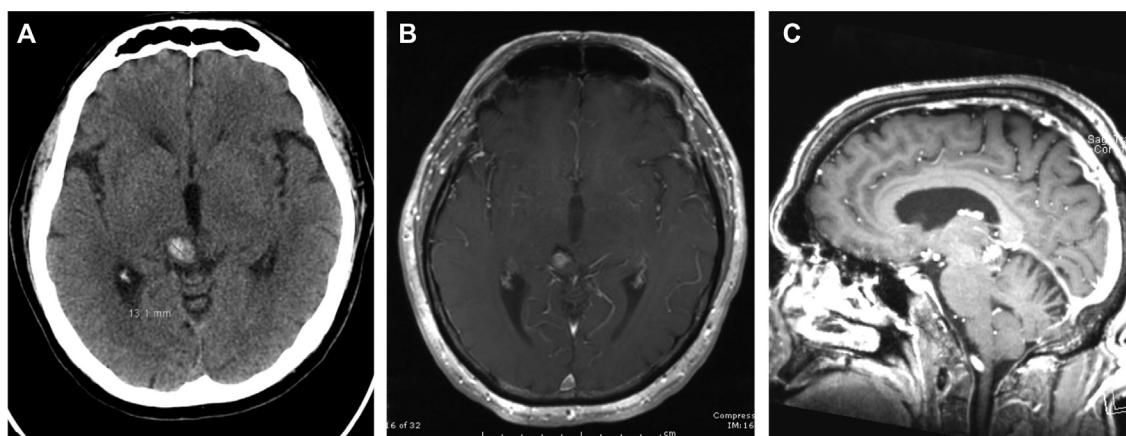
A. Axial non-contrast CT image showing a 1.3 cm brainstem hemorrhage. B. Axial gadolinium-enhanced T1-weighted MRI demonstrating a non-enhancing hyperintense lesion centered within the superior colliculus consistent with a subacute hemorrhage from a previously presumed cavernoma. C. Sagittal gadolinium-enhanced T1-weighted MRI showing the lesion in the dorsal midbrain.
